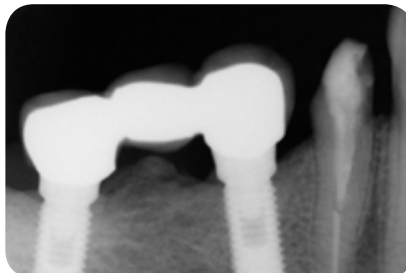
Evaluation with X-rays
